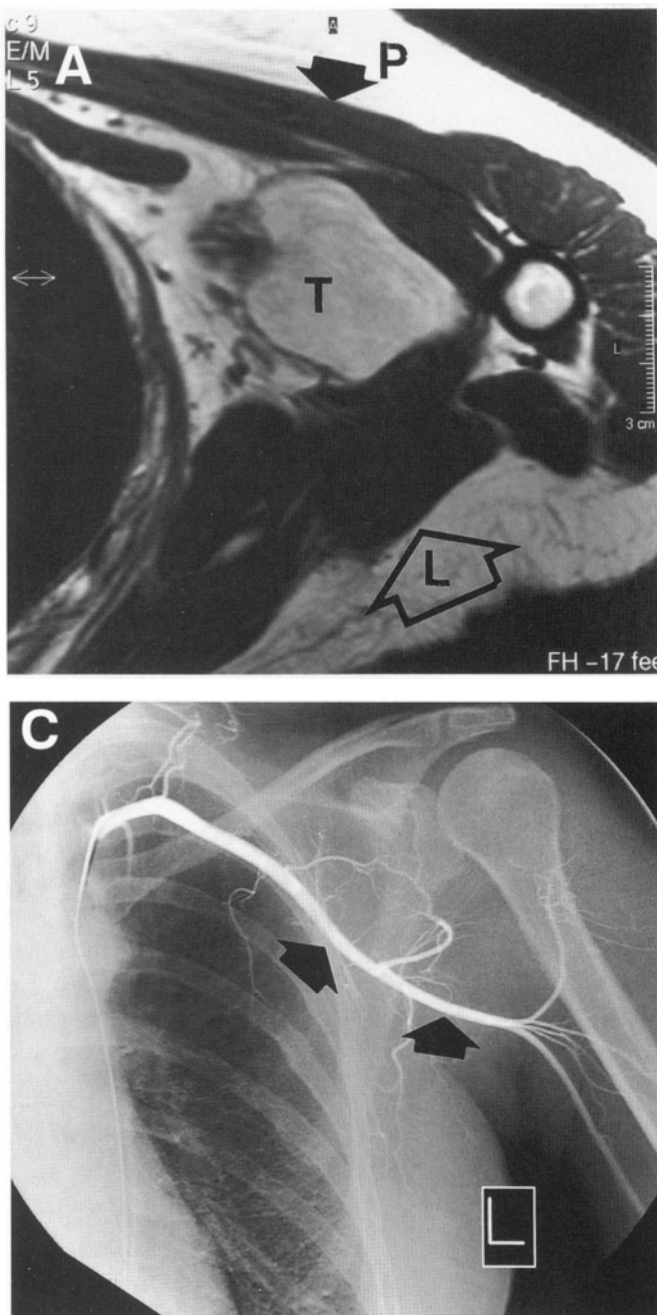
Liposarcoma (low grade) of the axillary space. (A) MRI of the left axilla demonstrates a large tumor (T) filling the axillary space. The axillary space is formed by the pectoralis major muscle (P) anteriorly; the latissimus dorsi (L) and the teres major muscles form the posterior border. This is a good demonstration of a primary tumor arising within the axillary space. (B) Coronal MRI. This T1-weighted image demonstrates the tumor (T) filling up the entire axillary space from proximal to the coracoid process (level 1) to the inferior margin. The neurovascular sheath (solid arrow) is displaced inferiorly. (C) AP angiogram corresponding to the coronal MRI demonstrates marked displacement of the axillary artery (arrows). This is an early arterial phase and demonstrates minimal vascularity.
